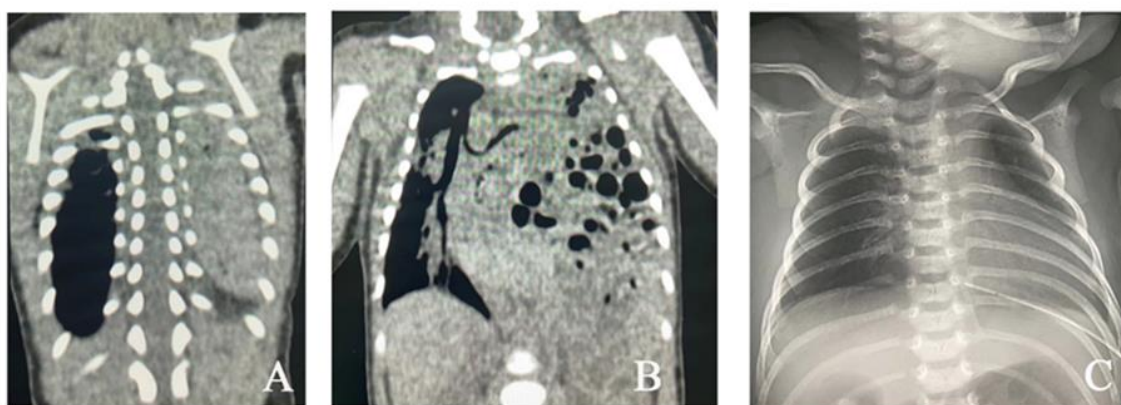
患儿手术前后胸部影像学检查。术前：A 患儿 CT 冠状位重建纵隔窗显示脾疝入左侧胸腔；B 患儿 CT 冠状位重建纵隔窗显示肠管疝入左侧胸腔；术后：C 患儿床旁胸片显示左侧膈疝术后，脾和肠管还纳复位。
